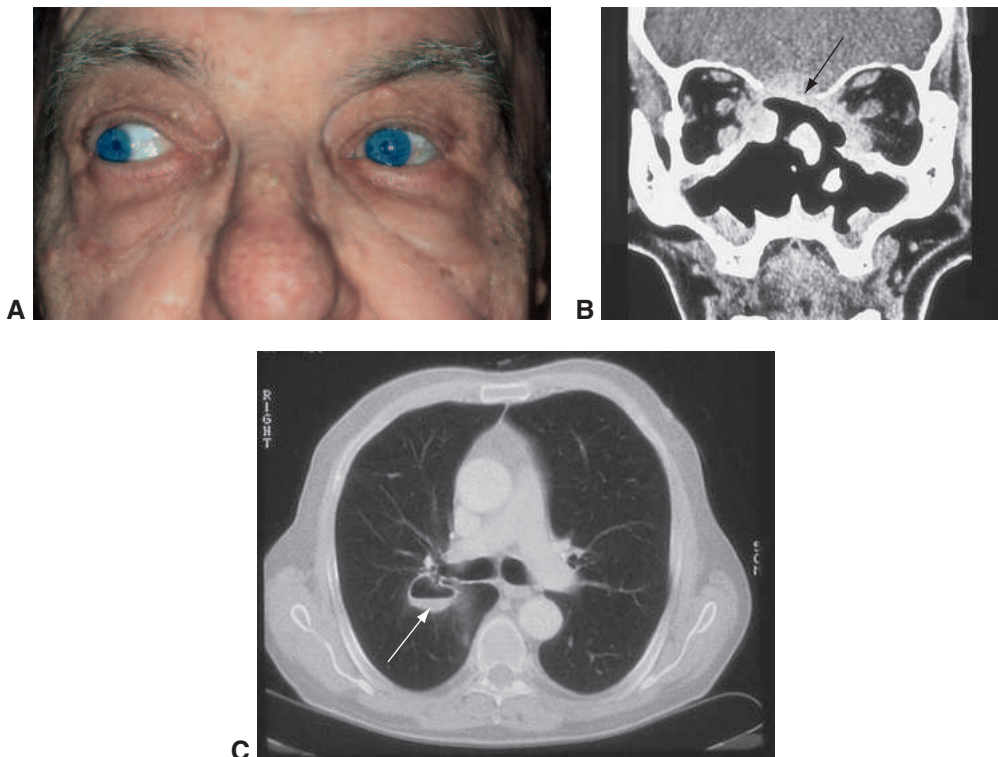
Granulomatosis with polyangiitis (GPA). A, Patient with restrictive strabismus of the left eye due to inflammatory tissue extending into the medial aspects of the orbit. B, Coronal CT scan shows extensive destruction of the nasal and sinus cavities with inflammatory tissue extending into orbits and brain (arrow). C, CT of chest shows cavitary lung lesions (arrow).
